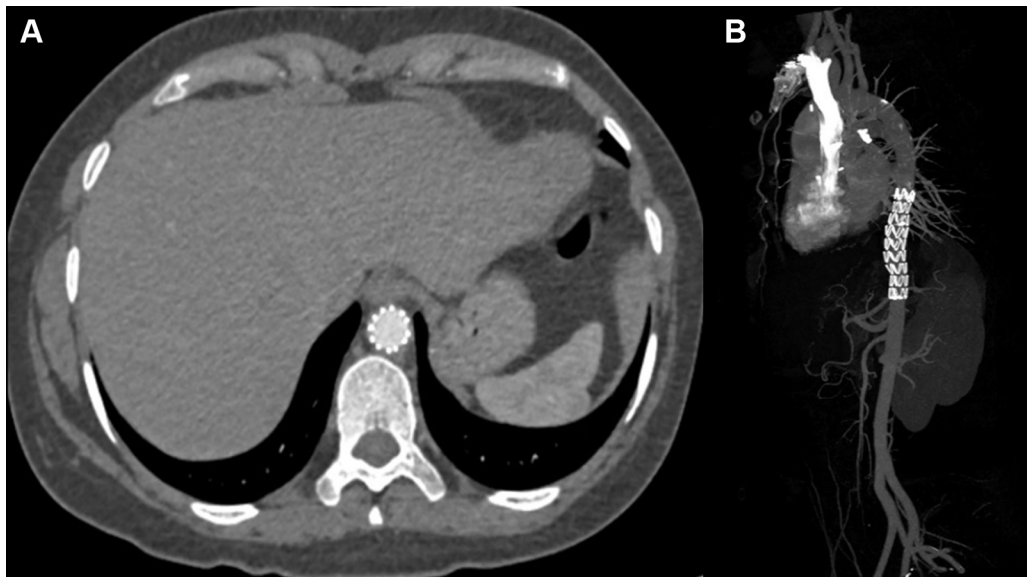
CTA of the Aortic Dissection in the Axial View
